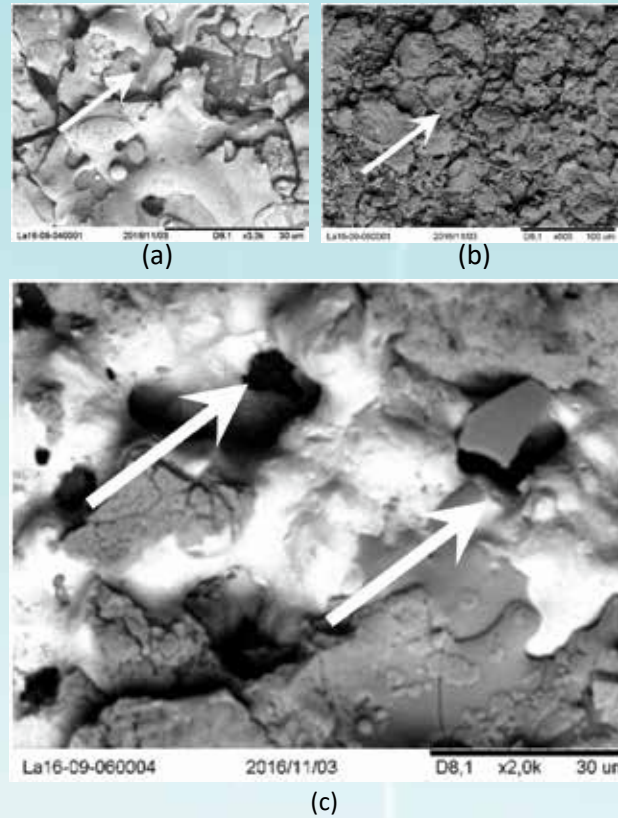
Plasma spray coated samples after ultrasonic bath. (a) HAP deposition, (b) TiO_2+HAp deposition, (c) $TiO_2+HAp+3$ wt.% Cu deposition.
